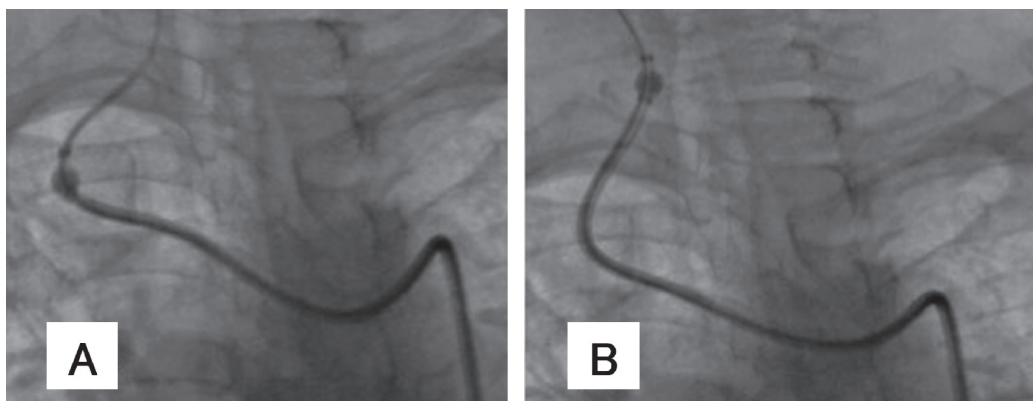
Balloon inflation for the navigation of the guide catheter—*intraoperative X-ray images showing the partial inflation of the balloon of an 8-F balloon guiding catheter that is used to aid in navigation.*
